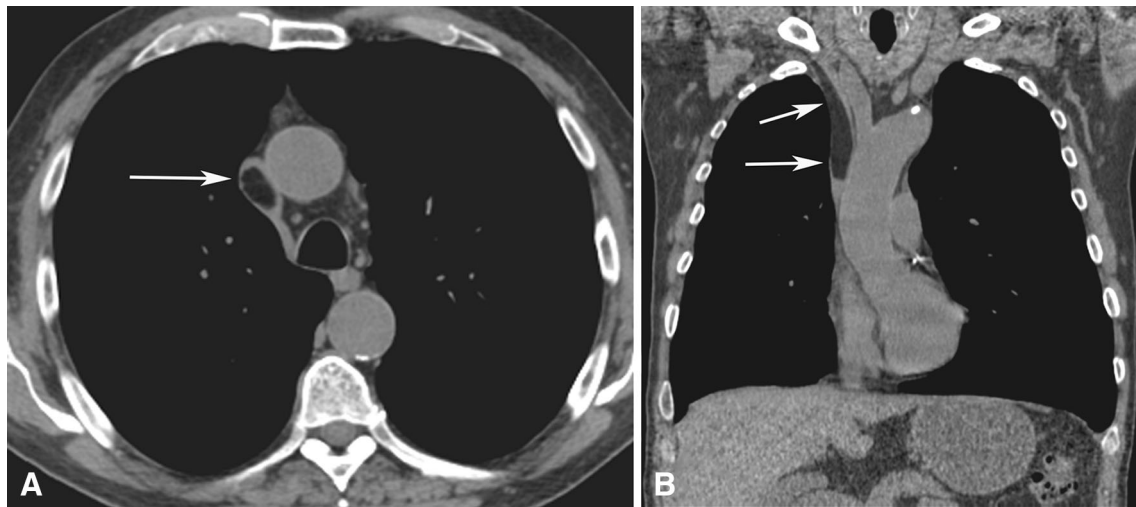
Unenhanced chest CT showing a hypodense elongated lesion with fat density within the superior vena cava (*arrows*)
